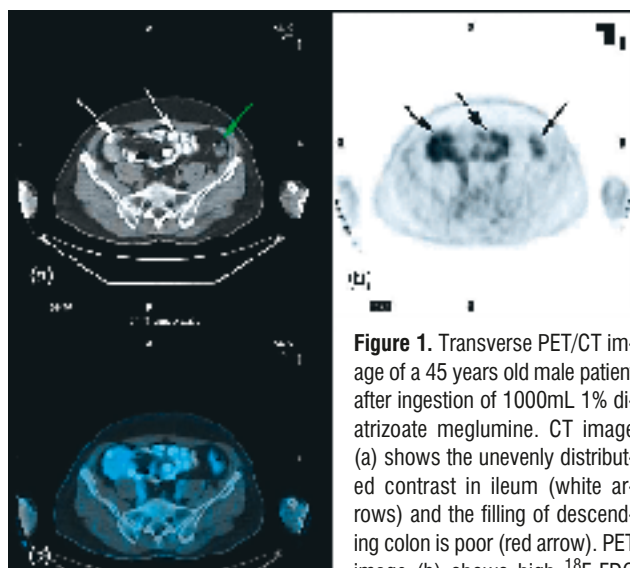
Transverse PET/CT image of a 45 years old male patient after ingestion of 1000mL 1% diatrizoate meglumine. CT image (a) shows the unevenly distributed contrast in ileum (white arrows) and the filling of descending colon is poor (red arrow). PET image (b) shows high ¹⁸F-FDG uptake in ileum and colon (black arrows). (c) is the fusion image.
